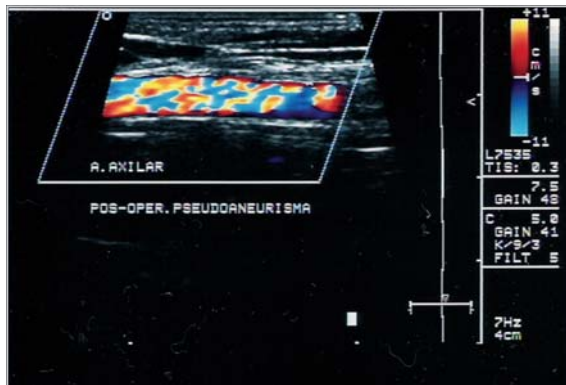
Photography of colour Doppler result showing the right axillary artery after surgical correction
